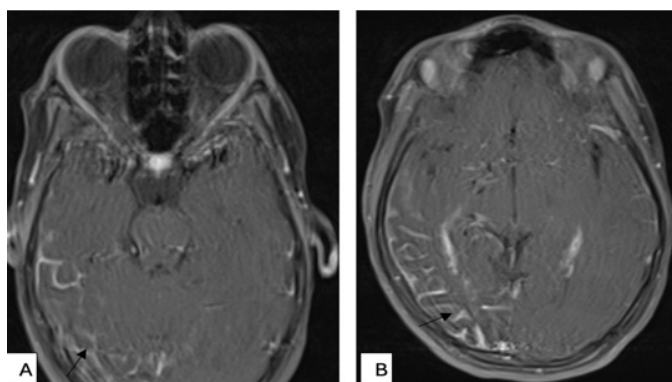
(A and B): Brain MRI with injection gadolinium showing a leptomeningeal angiomas (black arrow).
